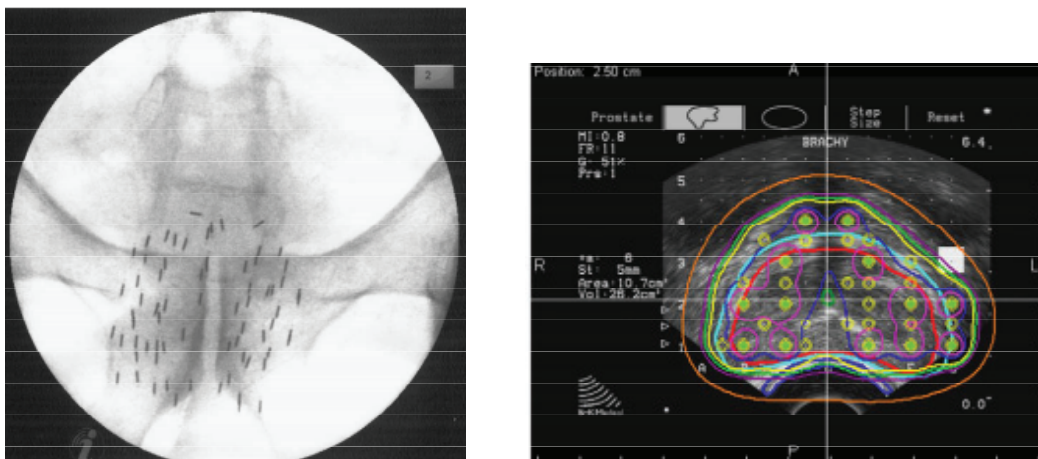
Permanent prostatic implantation in patients with localized (low-risk group) prostate cancer a) fluoroscopy showing the position of seeds b) the axial ultrasound imaging showing the prostate gland (red), 100% isodose (yellow) and seed position (green). (from Moule RN, Hoskin PJ. Non-surgical treatment of localised prostate cancer. *Surgical Oncology* 2009; 18: 255-267).
